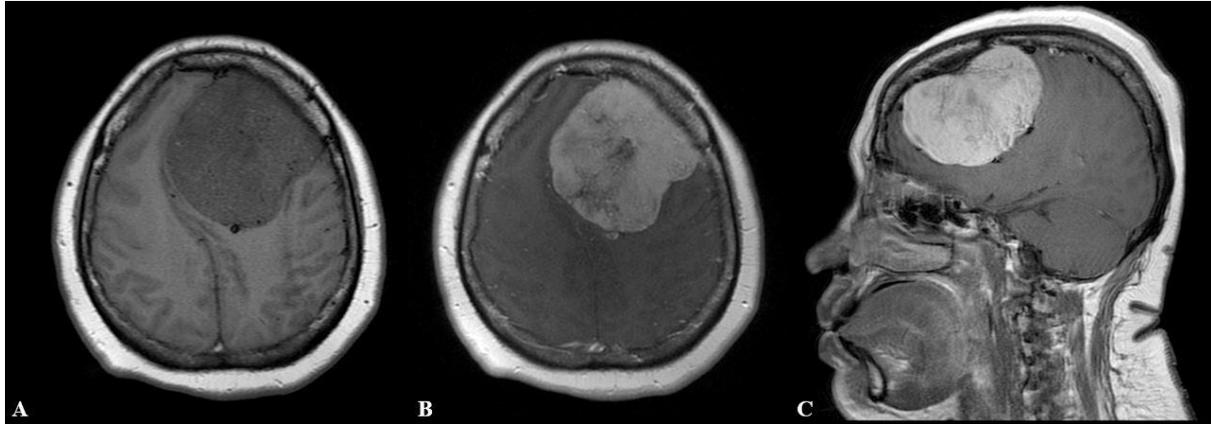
Head MRI of 44 y.o. female with fibroblastic meningioma, axial T1WI (A), axial T1 post-contrast (B), and sagittal T1 post-contrast (C). An extraaxial solid mass was present on left frontal convexity, causing visible midline deviation to the right. The mass demonstrated strong contrast enhancement on contrast administration. Slight hiperostosis was also noted from sagittal plane.
